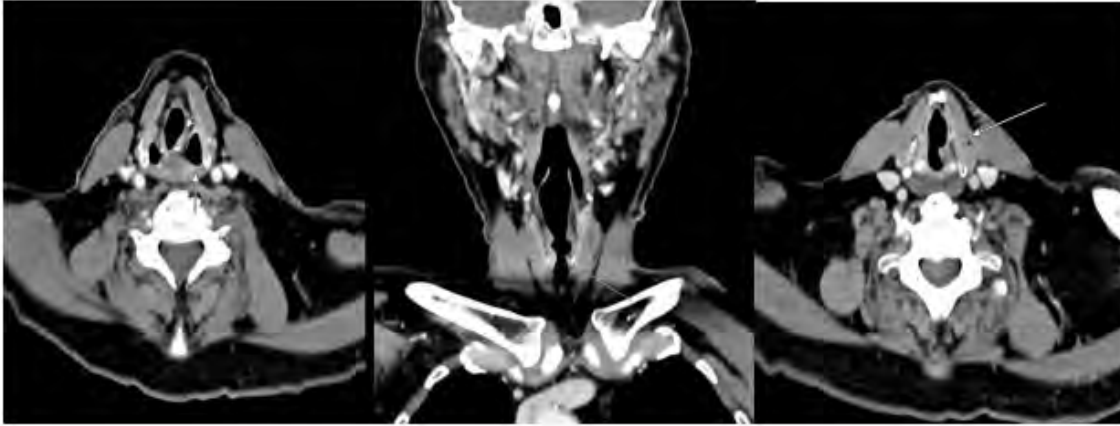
Contrast enhanced CT of the neck demonstrates thickening of the left aryepiglottic fold, asymmetric enlargement of the left piriform sinus and laryngeal ventricle, and thinning with medialization of the left vocal cord.
